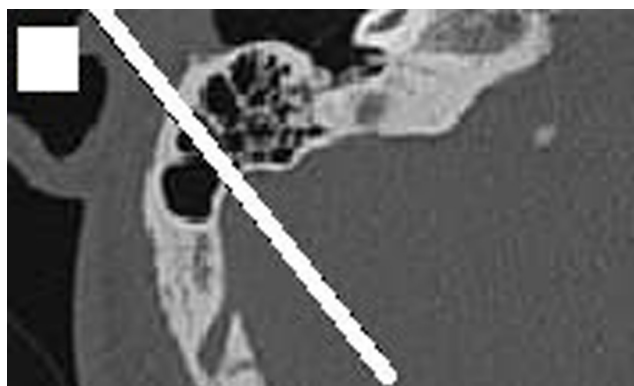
An axial cut of the right temporal bone HRCT, showing reasonable pneumatization of the mastoid as the air cells extend beyond the line passing through the anterior bulge of the sigmoid sinus (it was scored 0 marks). HRCT, high-resolution CT scan.
